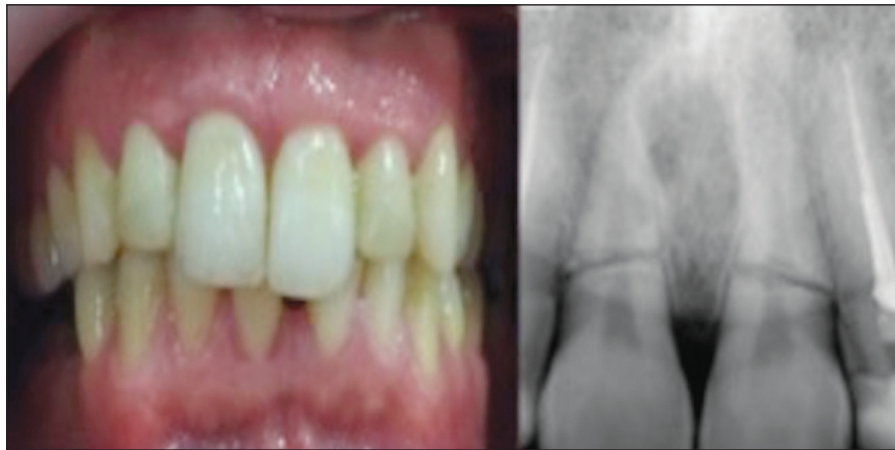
6-month follow-up clinical and radiological views. Periapical radiograph revealed the normal periodontal ligament spaces and there was no radiolucent lesion in apical area of the injured maxillary right and left first incisors without any canal treatment.
